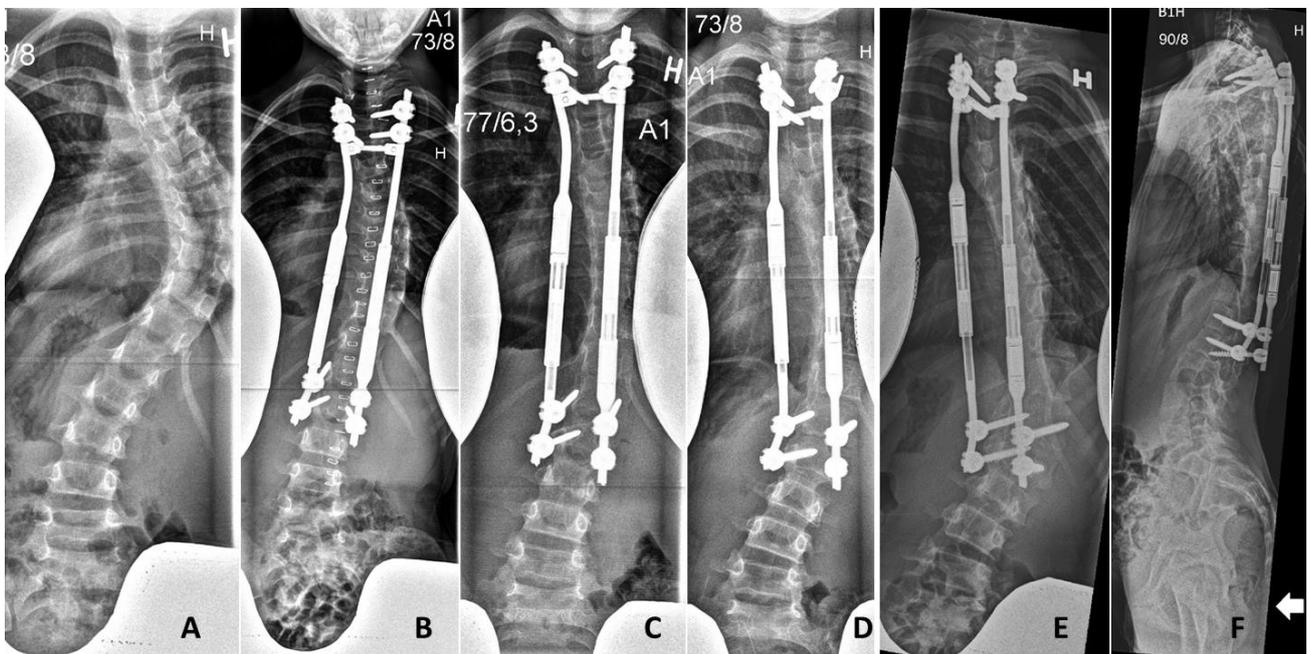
The very first patient operated in our cohort, 8 years old. This patient had a juvenile idiopathic scoliosis with a preoperative major curve angle of 77°. Radiographs shown are preoperative (A), postoperative (B), at 1.5-year (C), 3-year (D) and 4.5-year postoperatively, antero-posterior (E) and lateral (F). Postoperatively, major curve was reduced to 41°. After 1.5 years she developed pain at the distal anchor site. A CT-scan showed screw loosening and she was re-operated with exchange of both rods. She had undergone 27 distractions at latest
